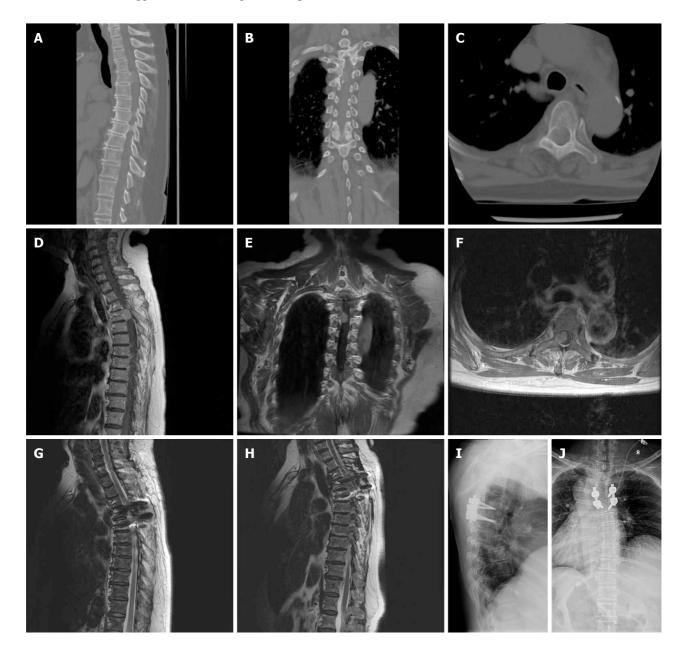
Imaging finding in case 1. A: Sagittal; B: Coronal; C: Axial 3-dimensional CT images revealed calcification within the tumor; D: Subsequent sagittal; E: Coronal; F: Axial magnetic resonance imaging T1-weighted post-contrast-enhanced images demonstrated homogeneous contrast enhancement of the tumor, which was located in the thoracic spine with ventrolateral dural attachment; G: Sagittal magnetic resonance imaging (MRI) T2-weighted image displayed gross-total resection of the tumor; H: Sagittal MRI T2-weighted image displayed no recurrence of the tumor observed 3 years after surgery; I: Lateral; J: Anteroposterior X-ray images depicted pedicle screw fixation and posterolateral bone graft fusion procedures that were conducted to stabilize the spine.
